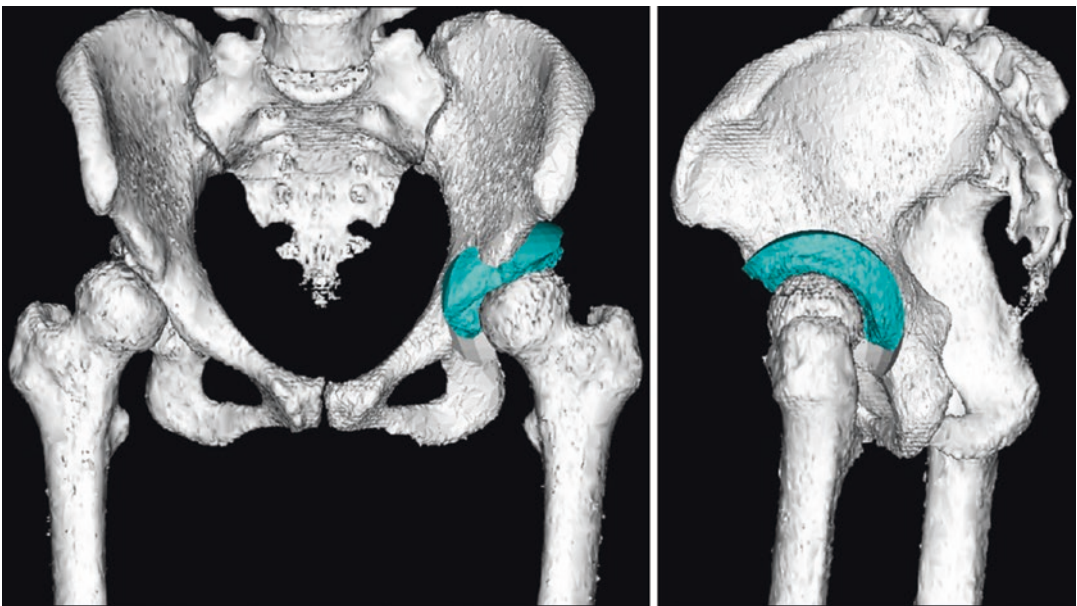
CT-based preoperative planning. The acetabular fragment (blue) is rotated 25° laterally
